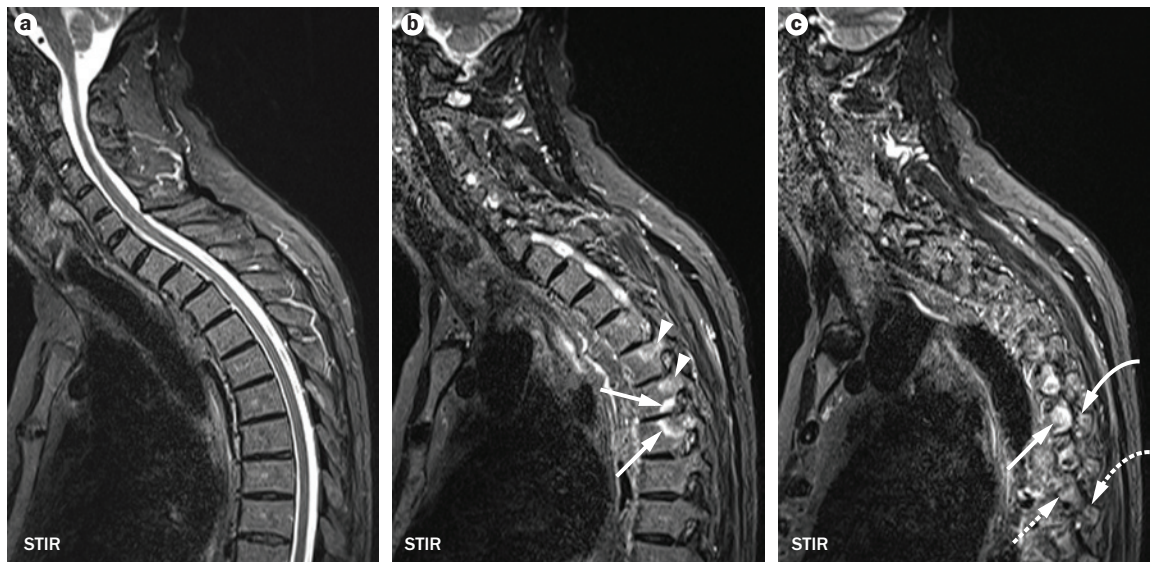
Spinal MRI can identify SpA-associated inflammation. Three MRI images with STIR sequence applied of a 48 year old, *HLA-B27* negative male patient with AS who presented with interscapular pain on deep breathing and rotation of the trunk. a | A central MRI slice, showing the central spinal canal, without inflammation. b | A lateral MRI slice through the pedicles displays bone marrow edema in the fifth and sixth thoracic vertebra, representing costovertebral joint inflammation (arrows). In addition, bone marrow edema is visible in pedicles (arrowheads). c | A far lateral MRI slice shows bone marrow edema both in the rib (straight solid arrow) and transverse process (curved solid arrow), corresponding to costotransverse joint inflammation. Broken arrows indicate a normal rib (straight broken arrow) and transverse process (curved broken arrow) for comparison. Inflammatory lesions in the lateral spinal compartment (costovertebral, costotransverse, and facet joint) are highly specific for SpA and can be captured by dedicated spinal MRI protocols for SpA that include lateral slices.^{62,65} Abbreviations: AS, ankylosing spondylitis; SpA, spondyloarthritis; STIR, short tau inversion recovery.
